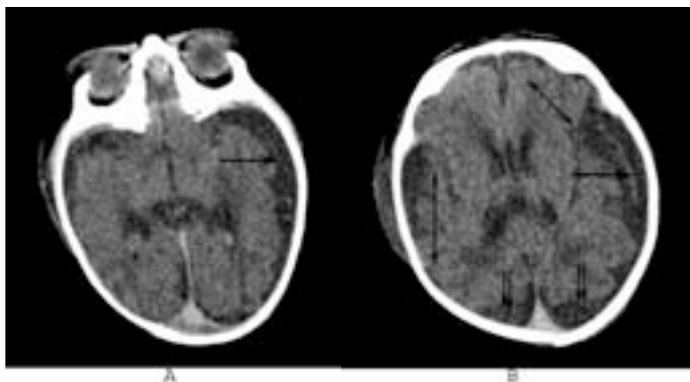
CT scan without contrast at 12 hours of life demonstrating pachygyria (double-headed arrows), right parietal hematoma (large single-headed arrows) and bilateral occipital hematomas (single-headed double arrows).
